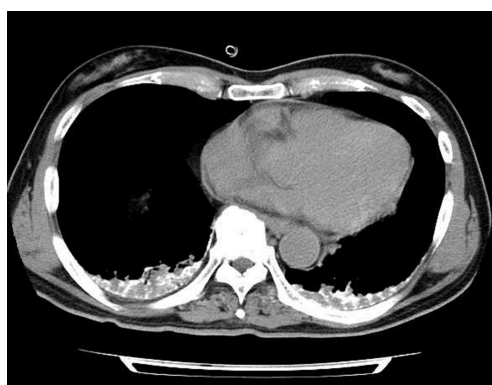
Chest computed tomography scan obtained 30 min after chemoembolization shows lipiodol deposition at both lung bases.
